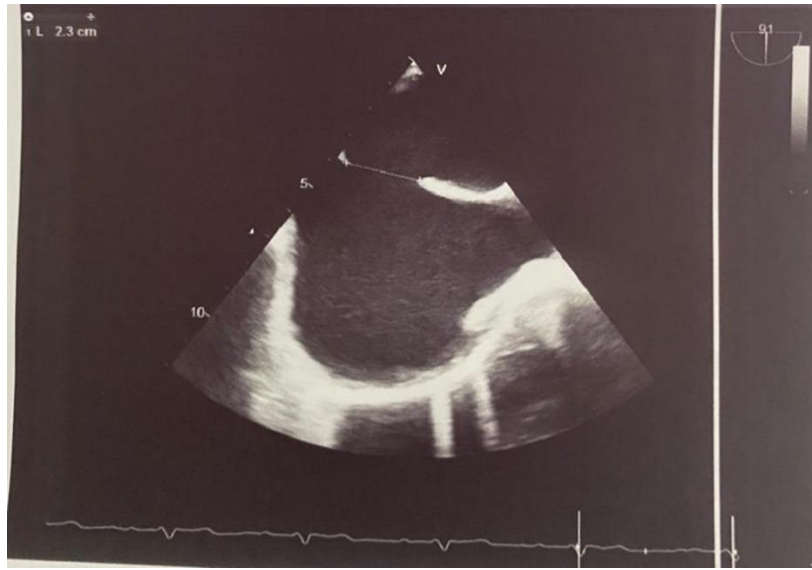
Transesophageal echocardiography shows a 23 mm ostium secundum ASD
